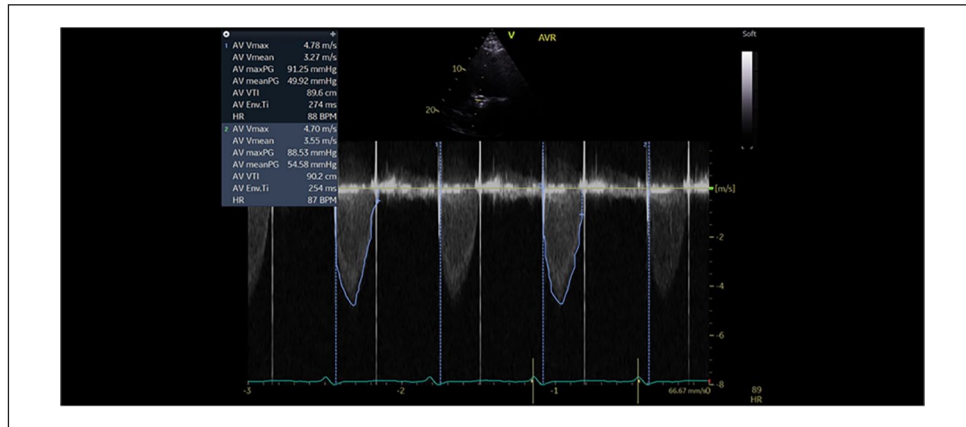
Initial transthoracic echocardiogram demonstrating severe stenosis of mechanical aortic valve with peak velocity of 4.7 m/s and mean pressure gradient of 52 mm Hg.
